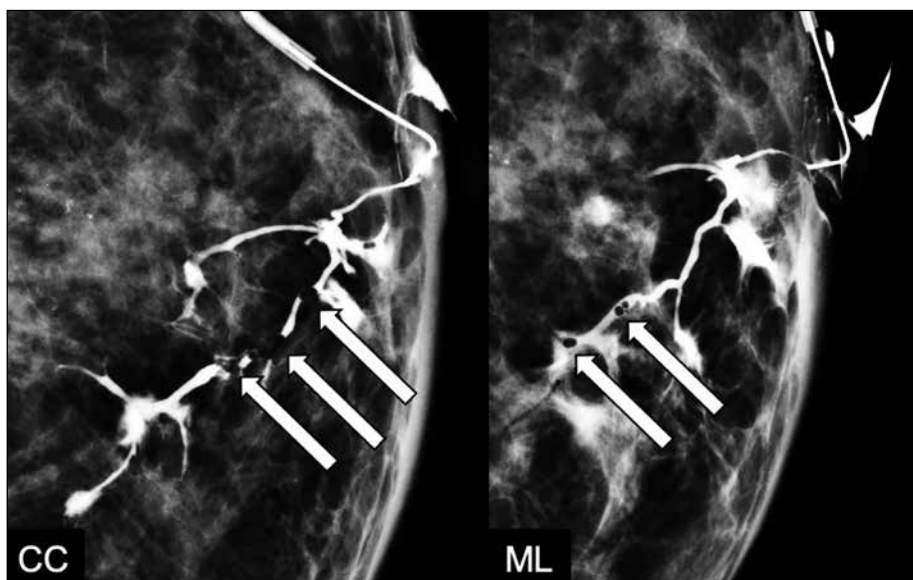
Ductography with craniocaudal (CC) and mediolateral (ML) views. Air bubbles seen as well-defined filling defects within the ducts, characteristically shifting in position between radiographs (arrows).
